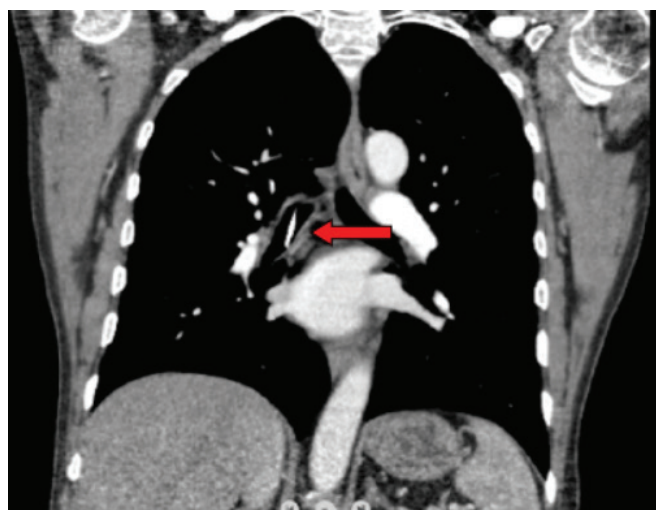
Mediastinal chest CT section demonstrating the chemotherapy port catheter eroding the bronchial wall and extending into the right bronchial system (red arrow).
